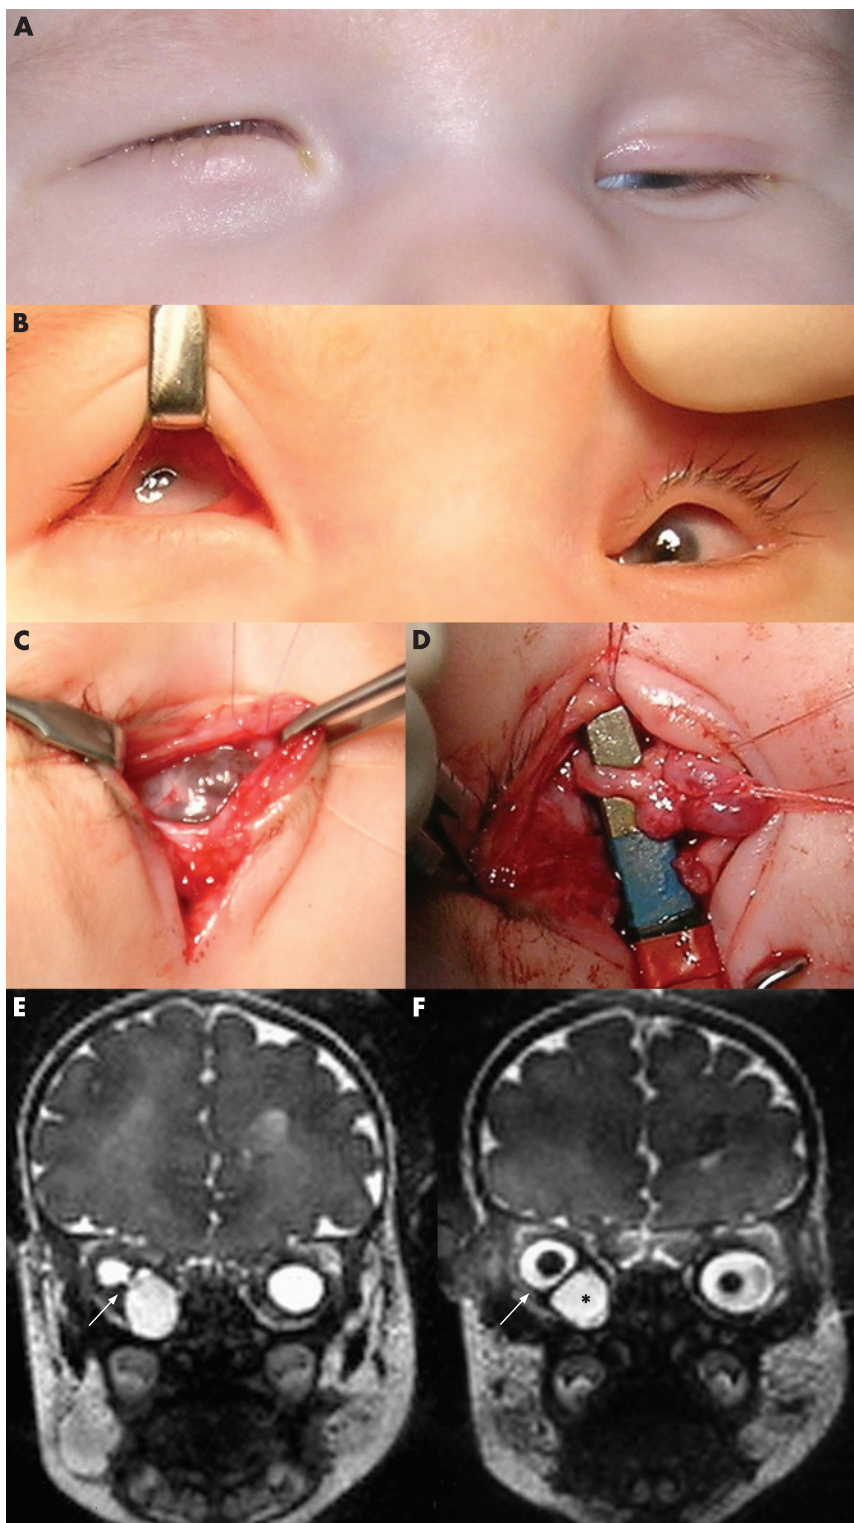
(A) External appearance of newborn with bilateral colobomatous microphthalmos with right orbital cyst. Note the bluish bulge in the right lower eyelid; (B) preoperative presentation of both eyes; (C) peroperative dissection of right orbital cyst; (D) intraoperative view of connective stalk between cyst and right microphthalmic eye; (E, F) Orbital T₂-weighted magnetic resonance imaging shows bilateral microphthalmos and large cyst in right orbit; (E) coronal view, demonstrating a connective stalk between microphthalmic eyeball and cyst (arrow); (F) coronal view, showing hyperintense cystic mass (black asterisk) causing superotemporal displacement of right microphthalmic eye (arrow).
